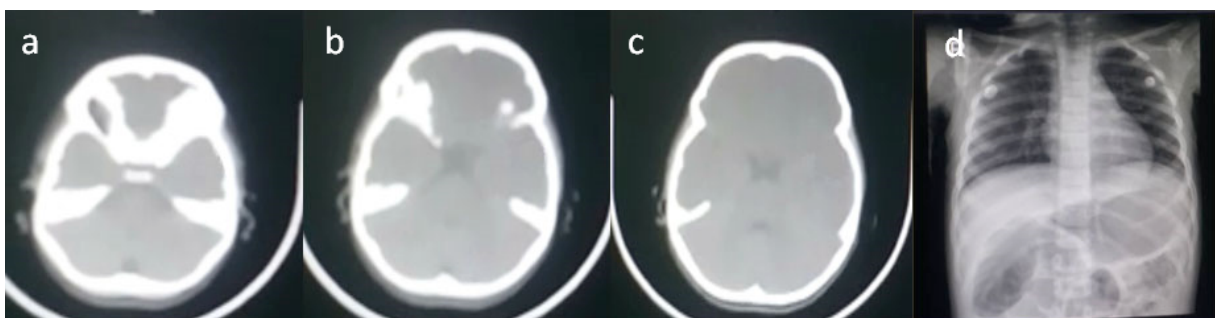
Radiographic imaging of the 3-year-old patient. (a-c) Brain CT and (d) Chest x-ray findings were normal.
